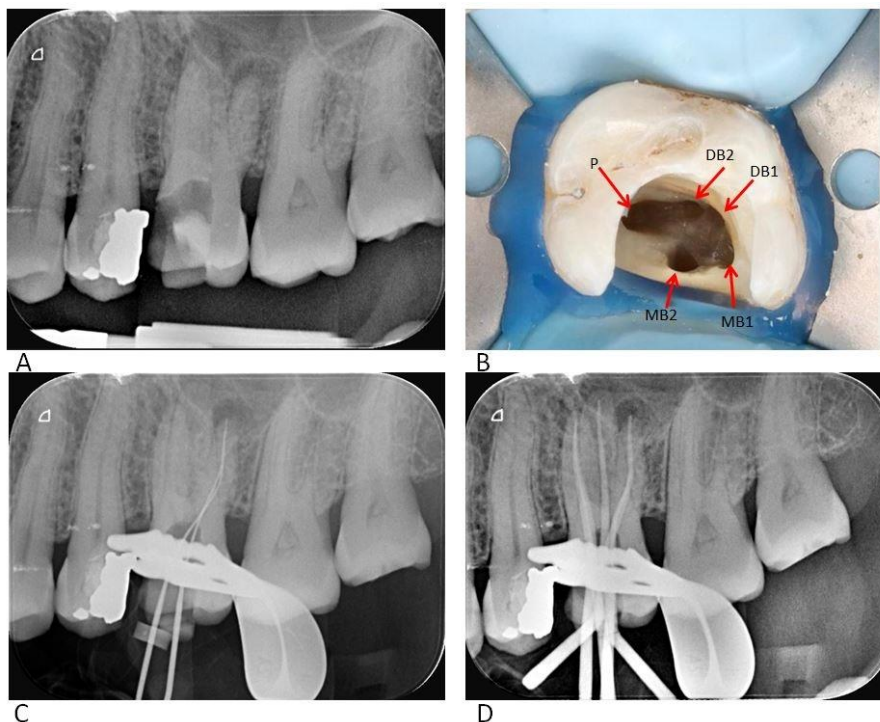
(A) Pre-operative periapical radiograph of tooth 26 showing occluso-mesial access cavity with remaining temporary restoration material and periapical radiolucencies associated with the MB and DB roots. (B) Clinical access cavity view after troughing revealing five canal orifices, including two adjacent and distinct DB orifices (DB1, DB2); MB1/MB2 and palatal canals also visible. Arrows indicate the location of the identified canal orifices. (C) Working length periapical radiograph taken with a mesial horizontal angulation (tube-shift technique), demonstrating separation of the DB1 and DB2 canals and their convergence at the mid-root level. (D) Master cone radiograph confirming canal configuration and working lengths
